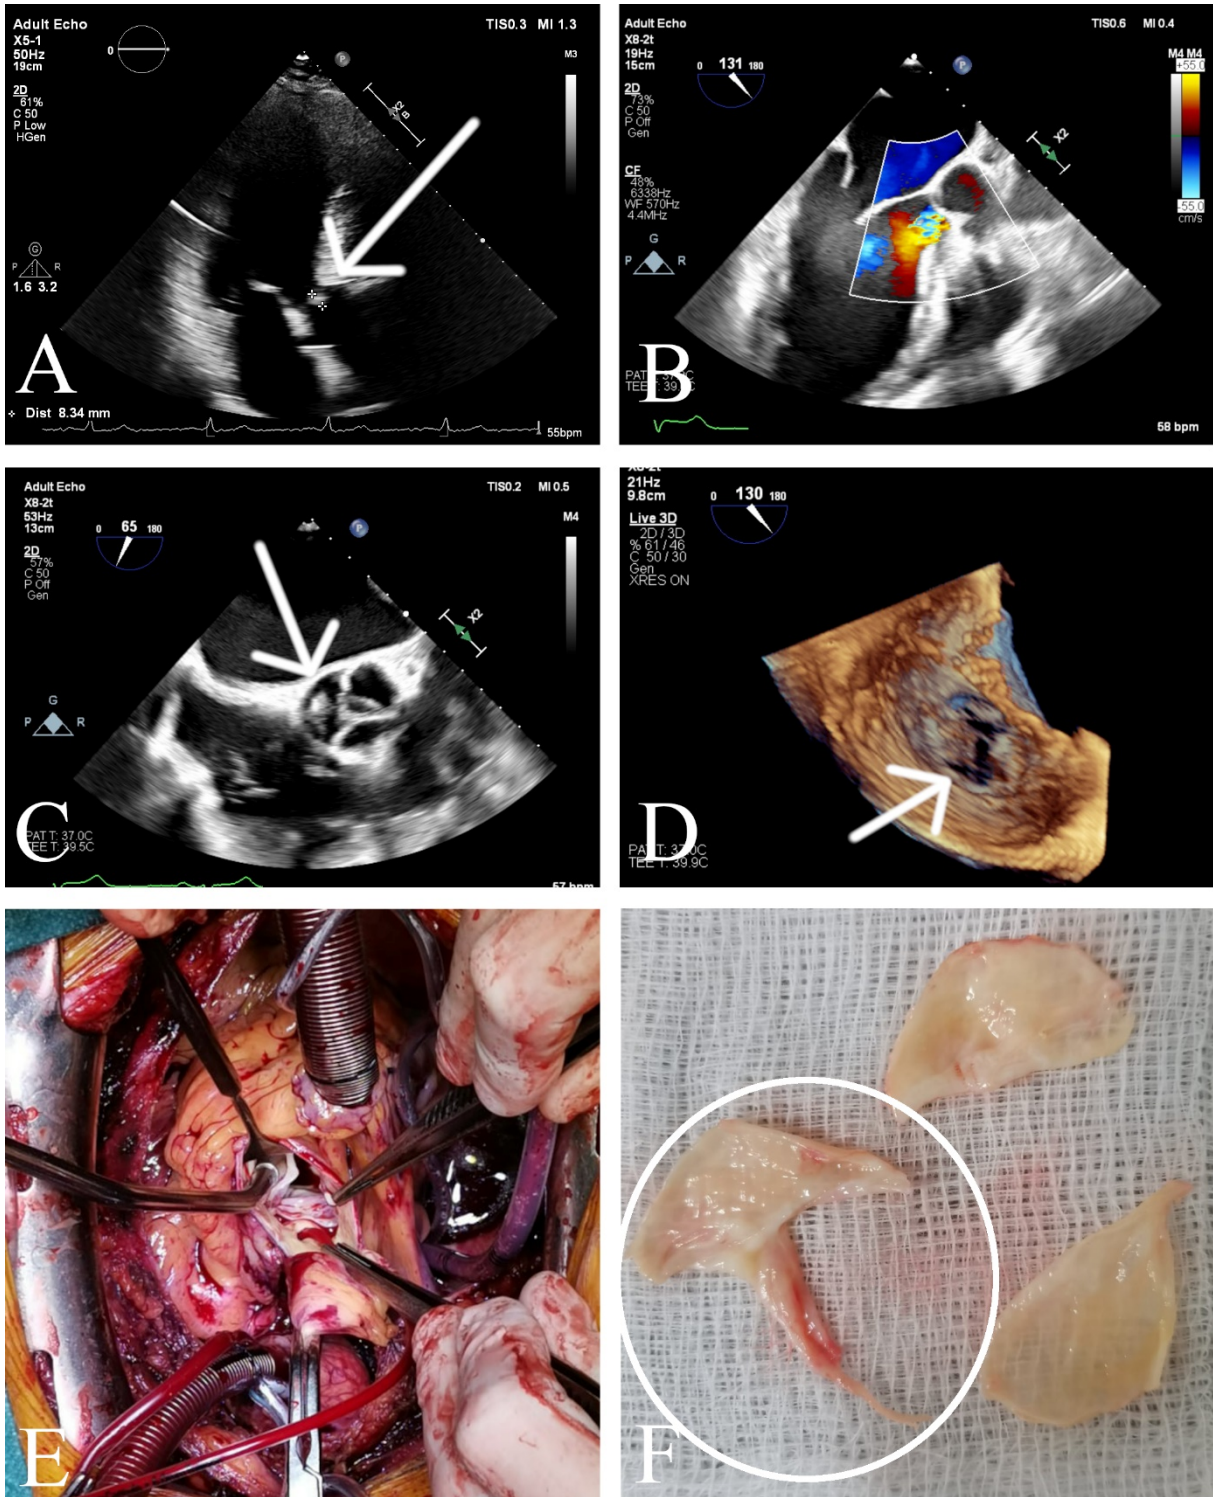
A. 2D transthoracic echocardiogram, apical 5 chamber view — 8 mm long structure in left ventricular outflow tract (arrow). B. 2D transesophageal echocardiogram, ME LAX view — severe aortic regurgitation. C, D. 2D and 3D transesophageal echocardiogram, ME aortic valve SAX view — perforation of non-coronary aortic cusp (arrows). E, F. The cardiac surgery with aortic valve replacement. The perforated cusp was marked with the circle
